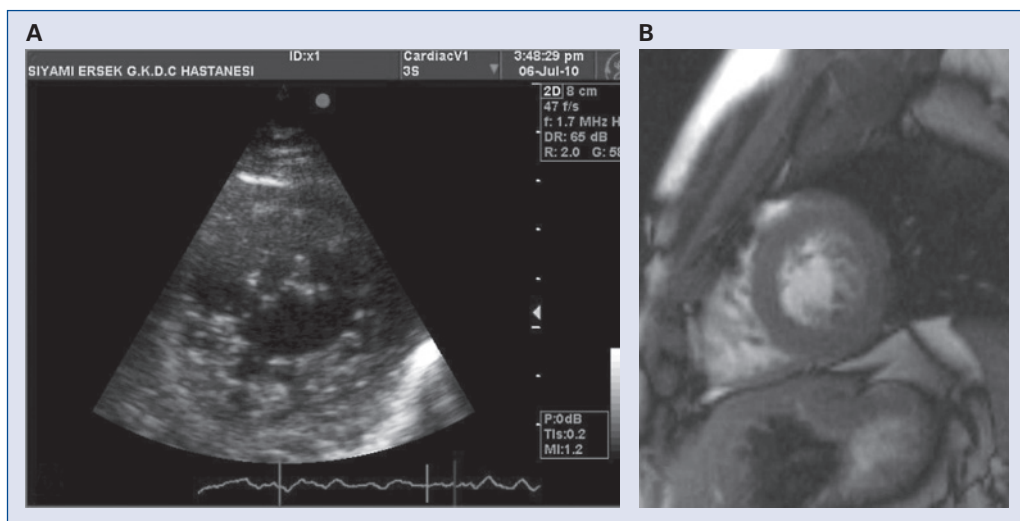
Echocardiogram (A) and cardiac magnetic resonance imaging (B) depicting noncompacted areas in lateral and inferior walls of left ventricle.
